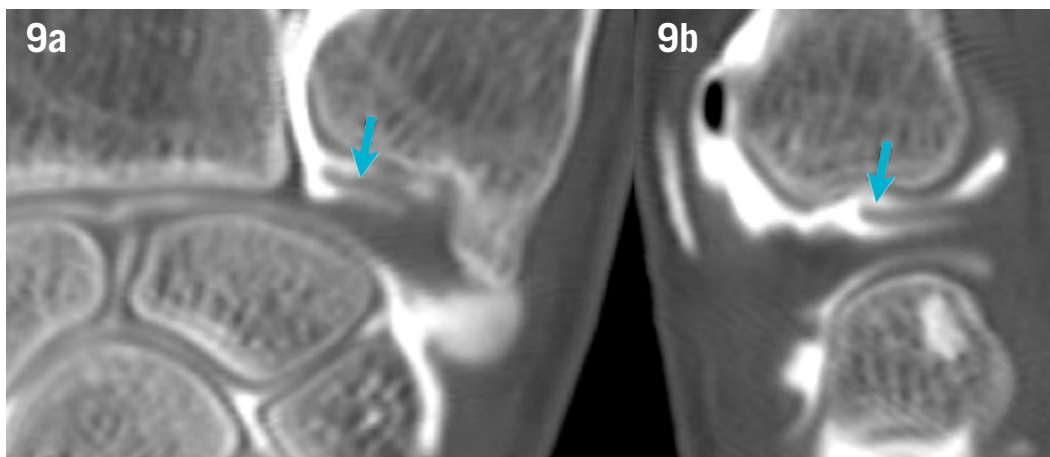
CT arthrography in coronal a) and sagittal b) planes shows a flap tear (arrows) of the articular disk of the triangular fibrocartilage complex.
